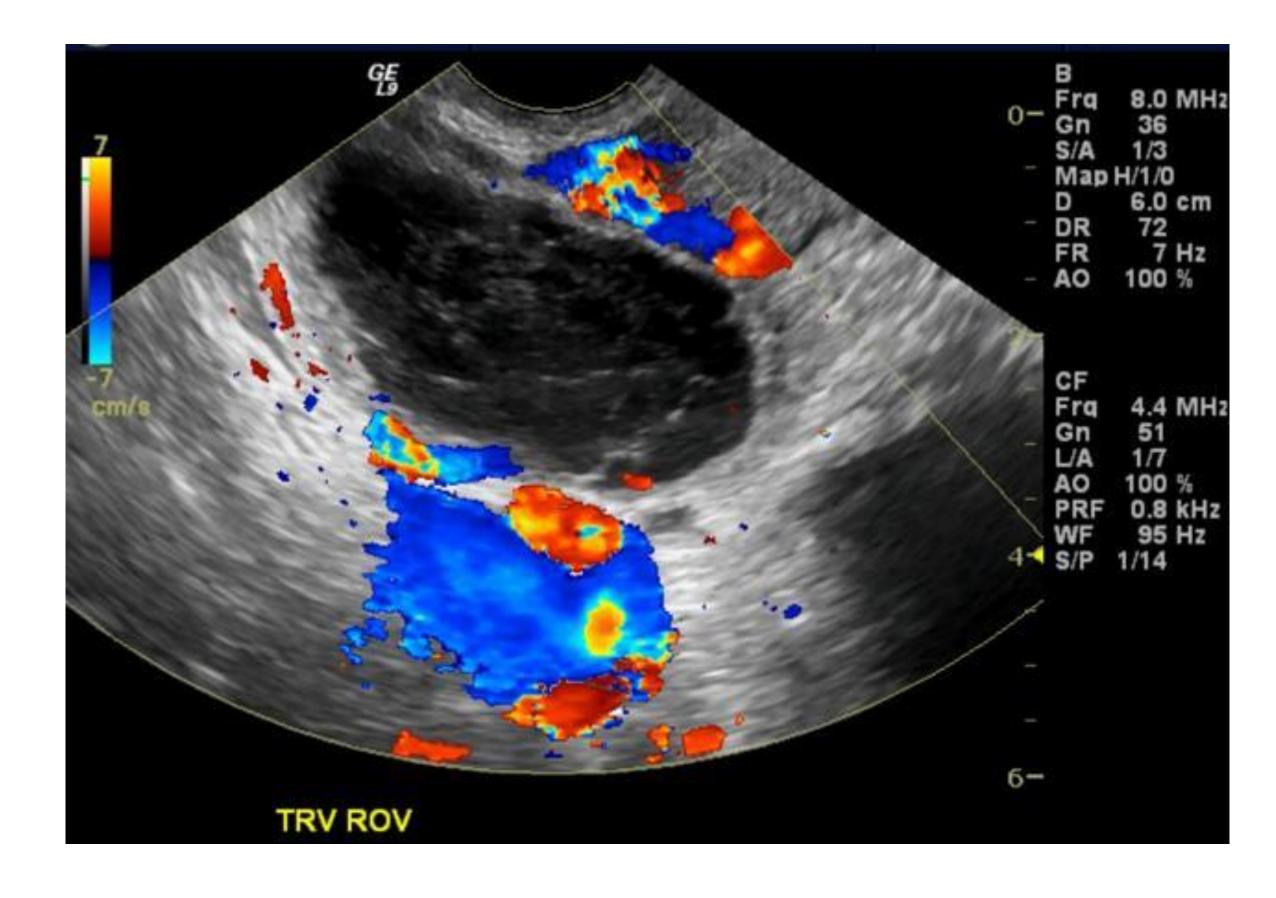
Ruptured ovarian cyst on ultrasound
